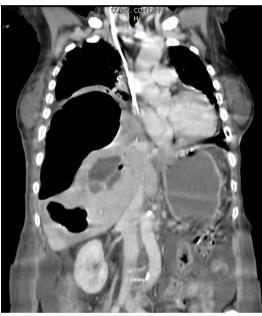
Thoracoabdominal CT scan, axial.
